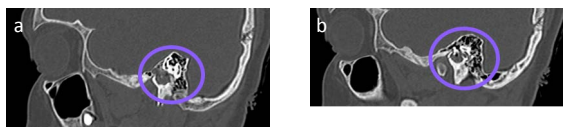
CT scan, sagittal plane: no destruction of the inner ear (a) and no dislocation of the ossicles, blood in the tympanic cavity (hemotympanum; b) (own clinical material)
